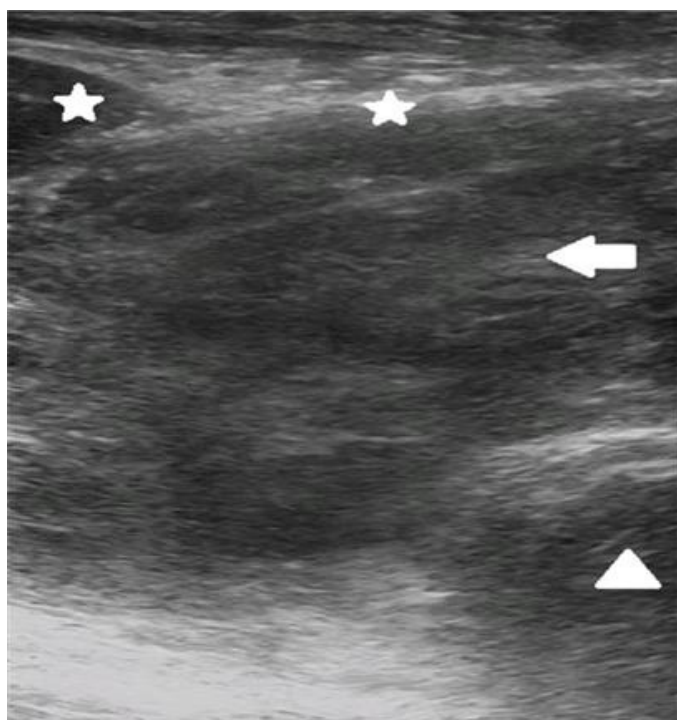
Ultrasound finding of a deep neck hematoma. * strap muscles; → hematoma; Δ trachea.
